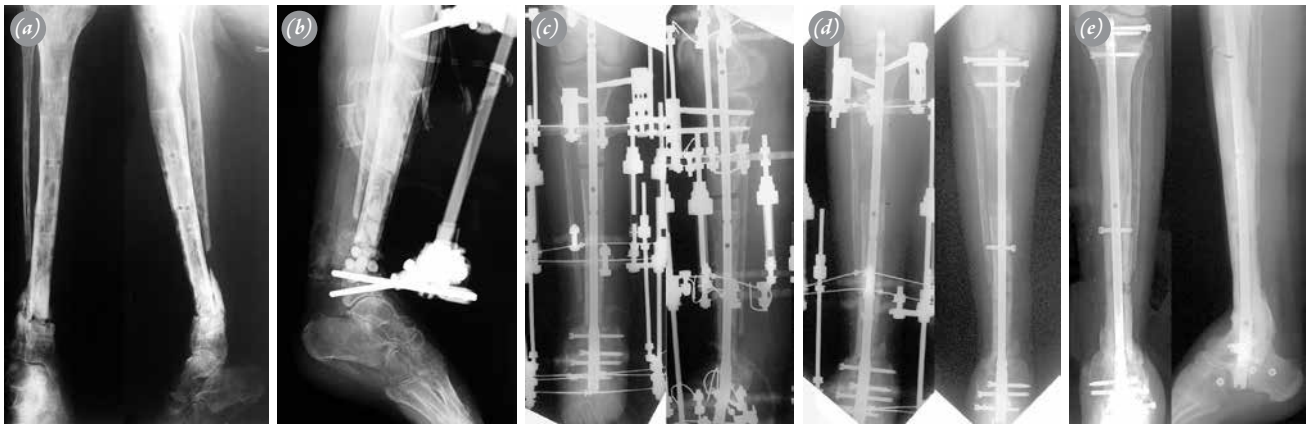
Case 11, a 28-year-old woman with surgical site infection-related osteomyelitis with a pathological fracture after resection of synovial sarcoma. (a) Photograph taken when the patient was first evaluated, showing the pathological fracture and infected nonunion of the distal tibia. (b) Radiograph taken after radical debridement and resection of infected bone, followed by insertion of antibiotic beads and a temporary external fixator to create dead space. (c) Postoperative anteroposterior radiograph showing the temporary knee fixation for limb length equalization and pantalar arthrodesis, with an intramedullary nail passing through the calcaneus, talus, tibia, and the circular external fixator. (d) Plain radiograph taken when the limb length equalization was completed before external fixator removal. Anteroposterior radiograph taken after the nonunion site was docked, the external fixator had been removed, and the locking screws had been inserted at the predrilled holes in the intramedullary nail. (e) Anteroposterior and lateral radiograph showing union at the arthrodesis site and the nonunion site.
